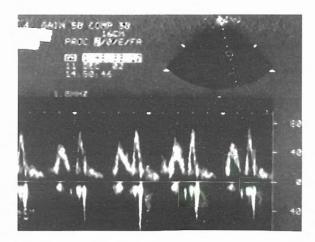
The patient's control pulse wave Doppler examination after 15 days of therapy that is not different from baseline measurements
